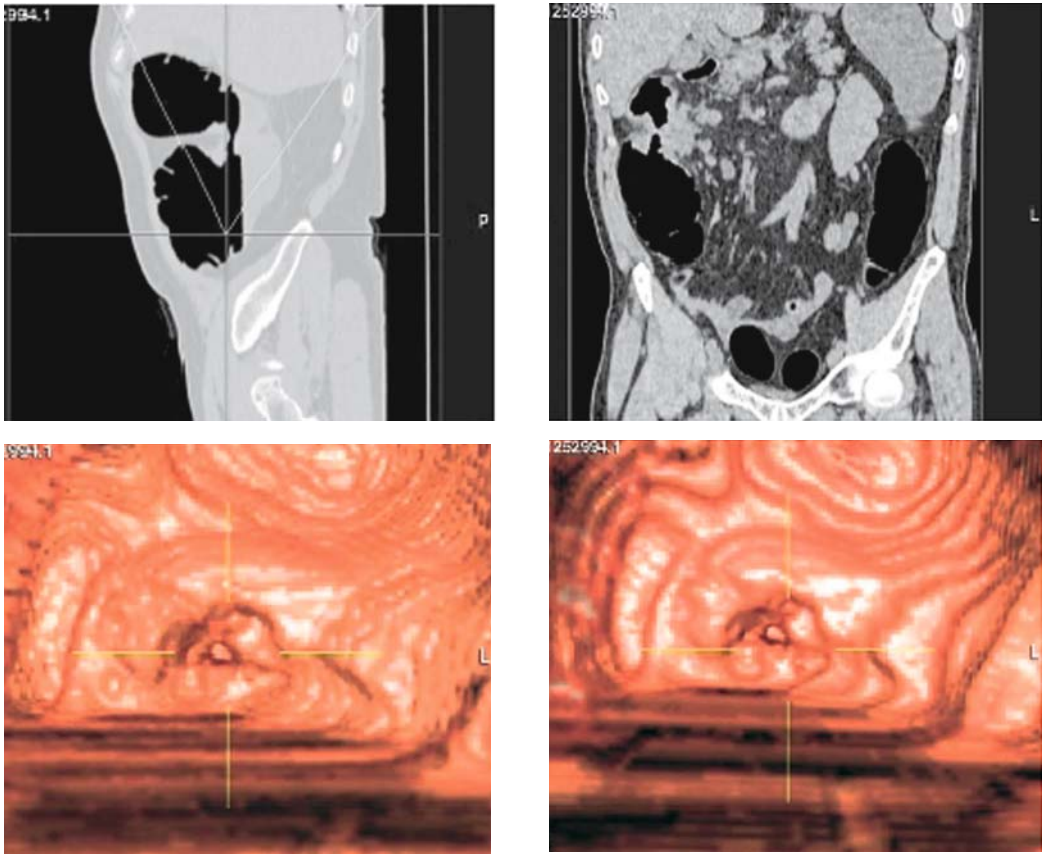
Multislice CT colonography. Colon tumour in 67-year old patient.
